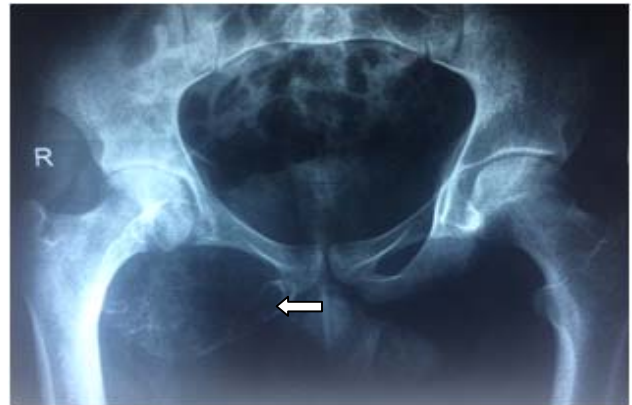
X-ray pelvis including both hip joints shows an expansile, multiloculated, lytic lesion with cortical thinning in the right ischio-pubic ramus (arrow).
